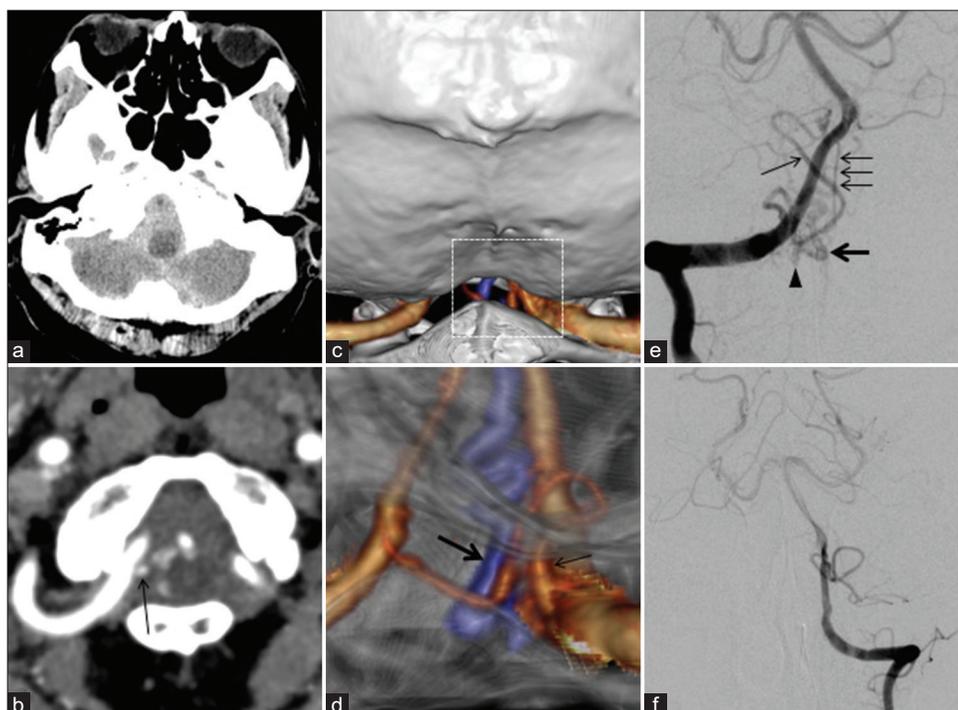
Computed tomography shows subarachnoid hemorrhage in the posterior cranial fossa (a). Computed tomography angiography shows abnormal blood vessels around the right vertebral artery (VA) at the C1 level (b-d). d represents an enlargement of the white dot square part of c. Right VA angiography shows an arteriovenous fistula draining into a radicular vein (e). Left VA angiography does not demonstrate vascular lesions (f). (Arrow: Right posterior inferior cerebellar artery, Thick arrow: Draining vein, Arrowhead: Shunt, Arrows: Anterior spinal artery).
